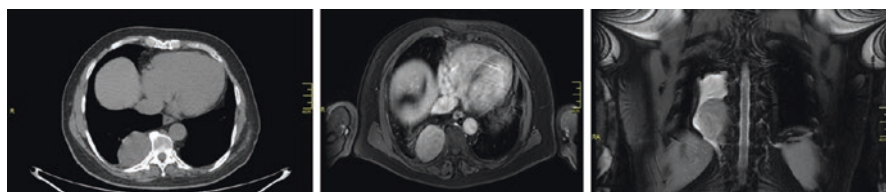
Chest MRI T2w sequence/chest TC without contrast: neuroma type A. In CT hypodense nodular formation in right paravertebral site and hypointense in MRI
